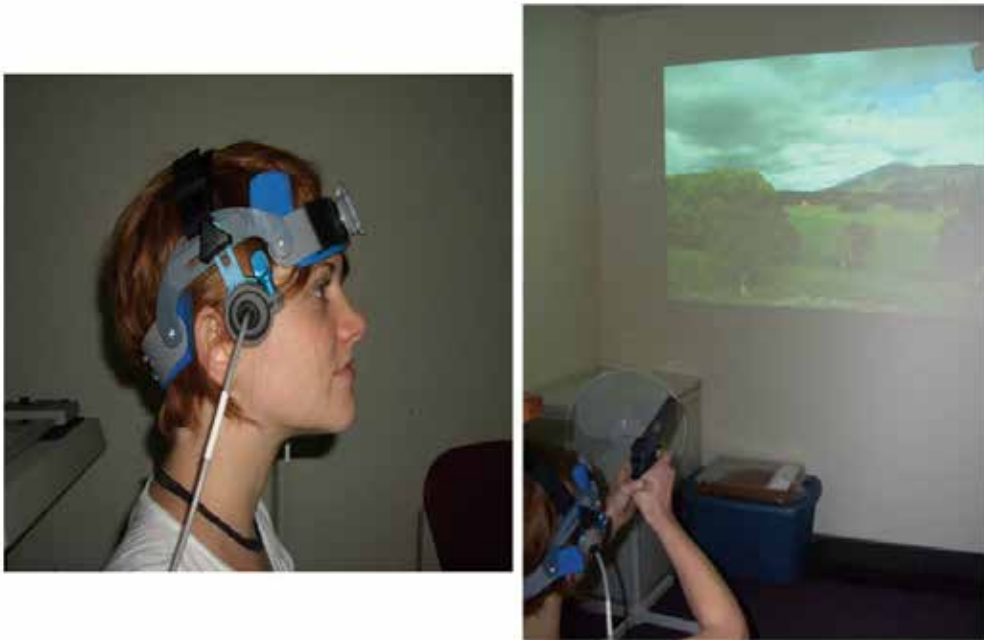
Apparatus used in the Schultz et al. (2009) study. Left: The Transcranial Doppler Sonography transducers positioned at the right and left (not pictured) transtemporal window for recording changes in cerebral blood flow velocity through the middle cerebral artery of each hemisphere. The two 2-MHz transducers are connected to a Companion III TCD system (Nicolet/EME, Madison, WI), which uses Fast Fourier analysis to transform the signals and displays mean CBFv for each heartbeat-cycle envelope. Right: The participant uses a laser-modified handgun to respond to computer-generated stimuli projected on a wall. Shots were automatically detected and recorded (time, location) by LaserShot (Stafford, TX) hardware and software
